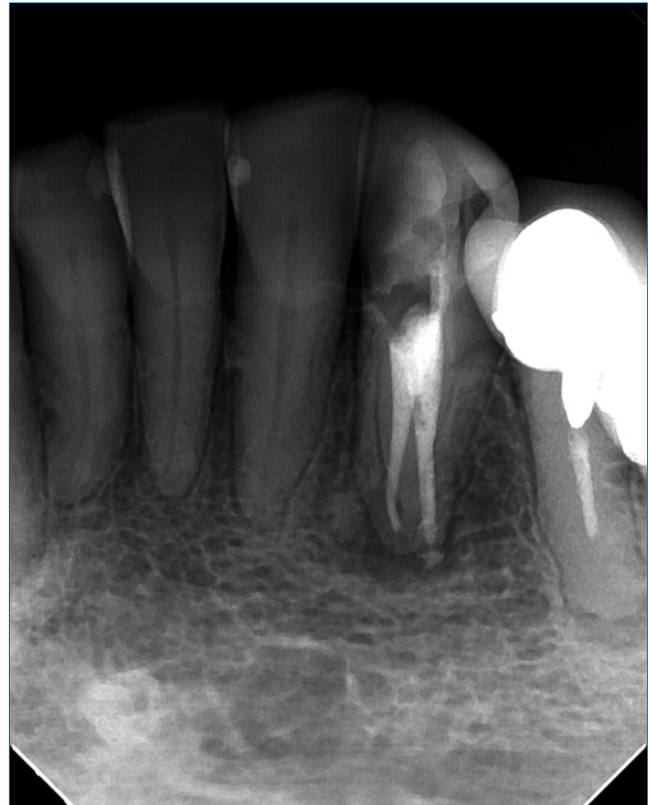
Final radiograph
